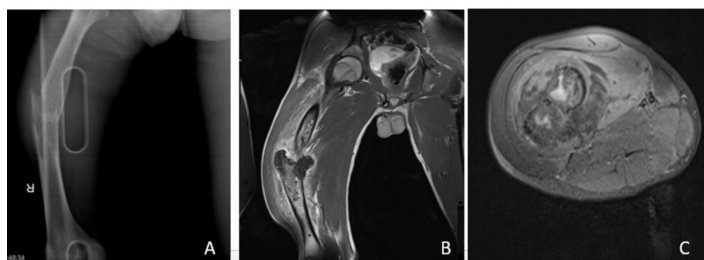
The 21-year-old man with Ewing sarcoma of bone showing (A) anterior-posterior and radiograph of the femur showing a lytic destructive lesion of the shaft. (B) MRI sagittal and (C) axial sequences show expansive destruction of the all cortex with a large associated soft-tissue mass.
